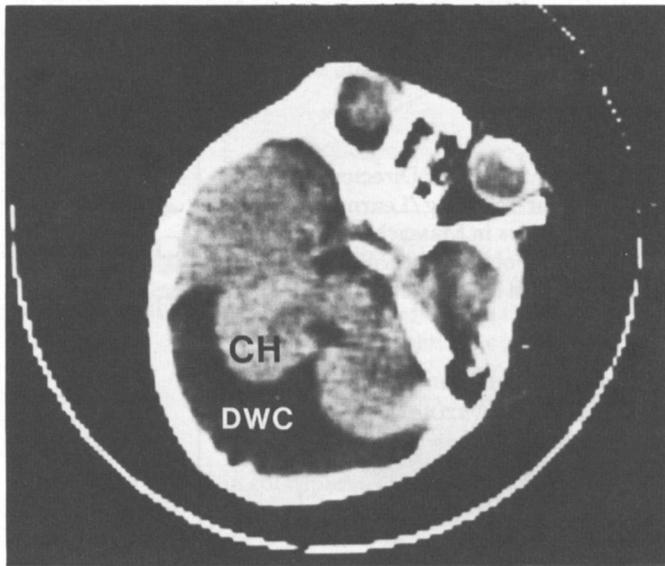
A CT brain scan of a baby with a Dandy-Walker cyst (DWC). The small, under-developed cerebellar hemispheres (CH) are clearly seen.
